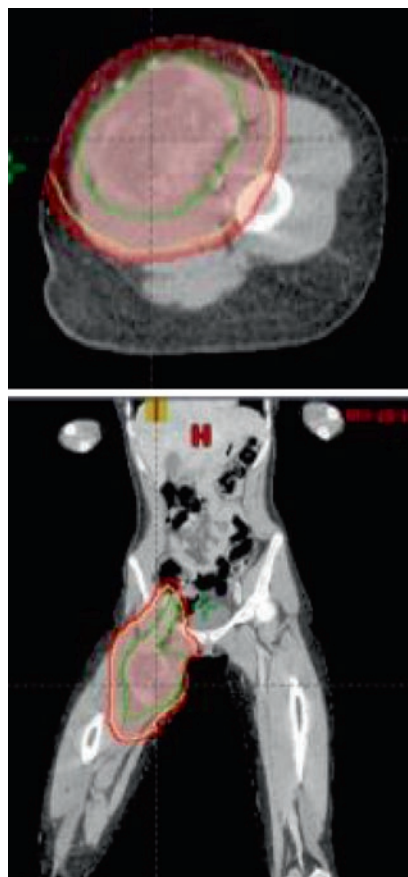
Contouring the CTV (yellow). (a) The CTV includes a 1.5 cm radial expansion on the GTV and is edited to exclude anatomic borders to tumor spread such as the small bowel, bone, and perineum. The right ovary is marked in orange at the level of the right acetabulum. The fascial plane between the deep muscle compartment and subcutaneous tissues also acts a barrier to tumor spread. As there was no subcutaneous tissue tumor infiltration nor biopsy tract, the CTV expansion was cropped to exclude subcutaneous tissue except in areas where there was potential for uncertainty in daily setup. (b) CTV should include suspicious edema as seen on MRI (red arrows)
